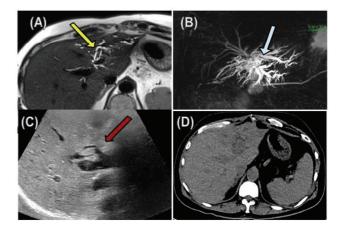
A 62-year-old male patient living donor liver transplantation (LDLT) 2 years back with elevated bilirubin. T2 HASTE (Half fourier Single-shot Turbo spin-Echo) axial image showed focal hypointense filling defect (A, yellow arrow) in the proximal left hepatic duct—may represent calculous/dense sludge. Maximum intensity projections of biliary system (B, white arrow) show multiple dilated intrahepatic biliary radicles predominantly on the left side (blue arrow), secondary to short segment stricture involving the junctions of the left and right hepatic duct confluence. Ultrasound (USG) correlation image revealed echogenic focus (C, red arrow) with no posterior acoustic shadowing. Corresponding axial computed tomography (CT) image (D) showed no e/o radiodense focus within the left hepatic duct, s/o dense biliary sludge/cast.
